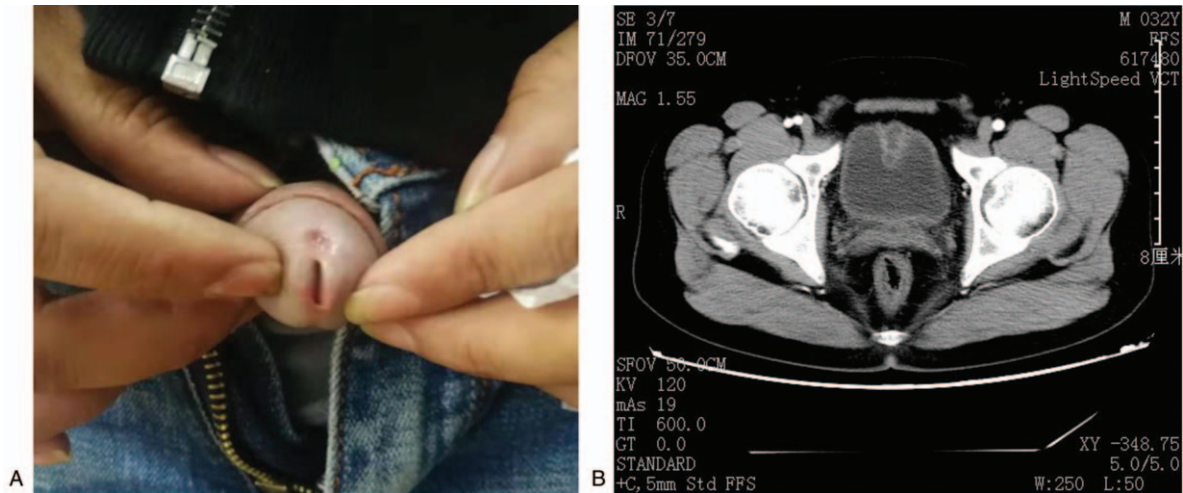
(A) Heterotopic sinus on the dorsal side of the normal external urethral orifice. (B) CT scan demonstrates a cystic mass next to the anterior wall of urinary bladder. CT=computed tomography.
